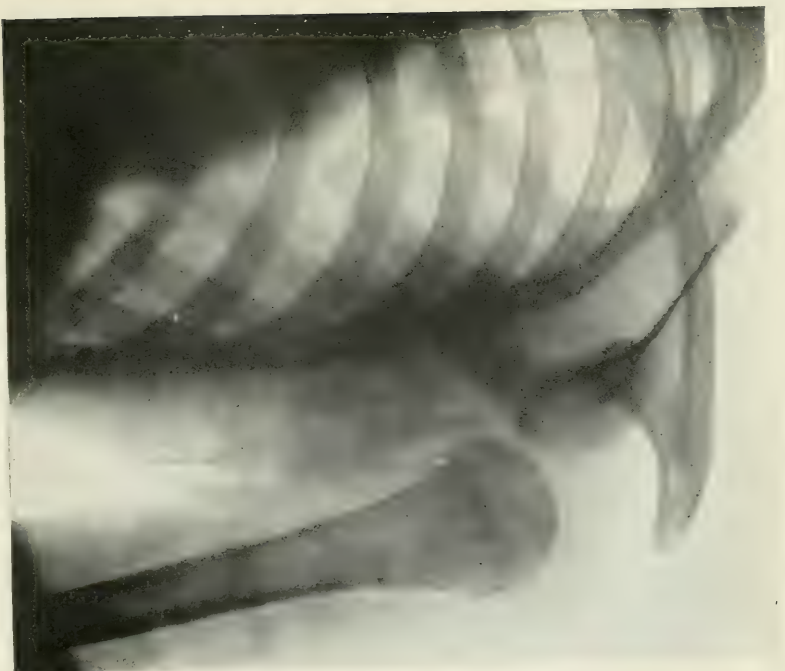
Radiograph showing persistent subglenoid dislocation of shoulder.
